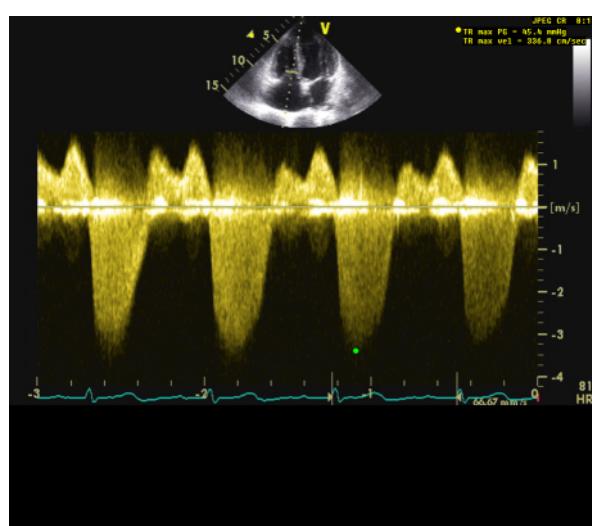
Transthoracic echocardiogram; continuous wave Doppler through a tricuspid valve.
